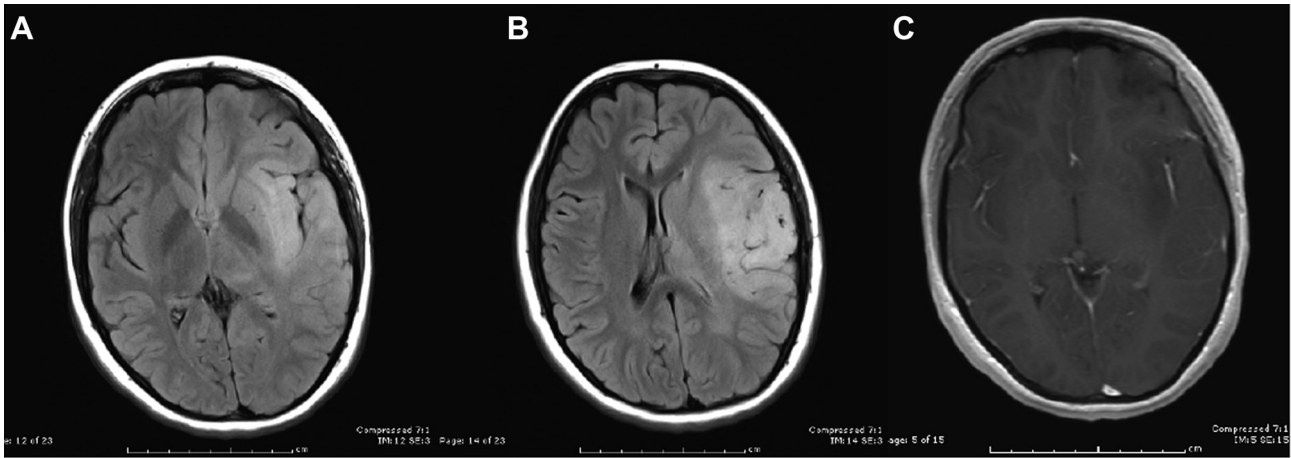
(A and B) Left inferior frontal, temporal and insular region of FLAIR hyper intensity involving both white matter and cortex. (C) There was no contrast enhancement on axial T1-weighted gadolinium enhanced MRI.
